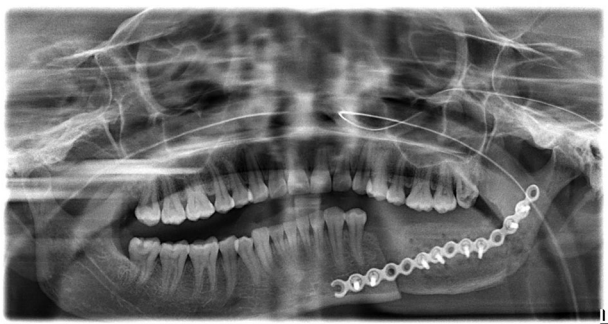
Post-operative orthopantomograph revealing reconstruction
